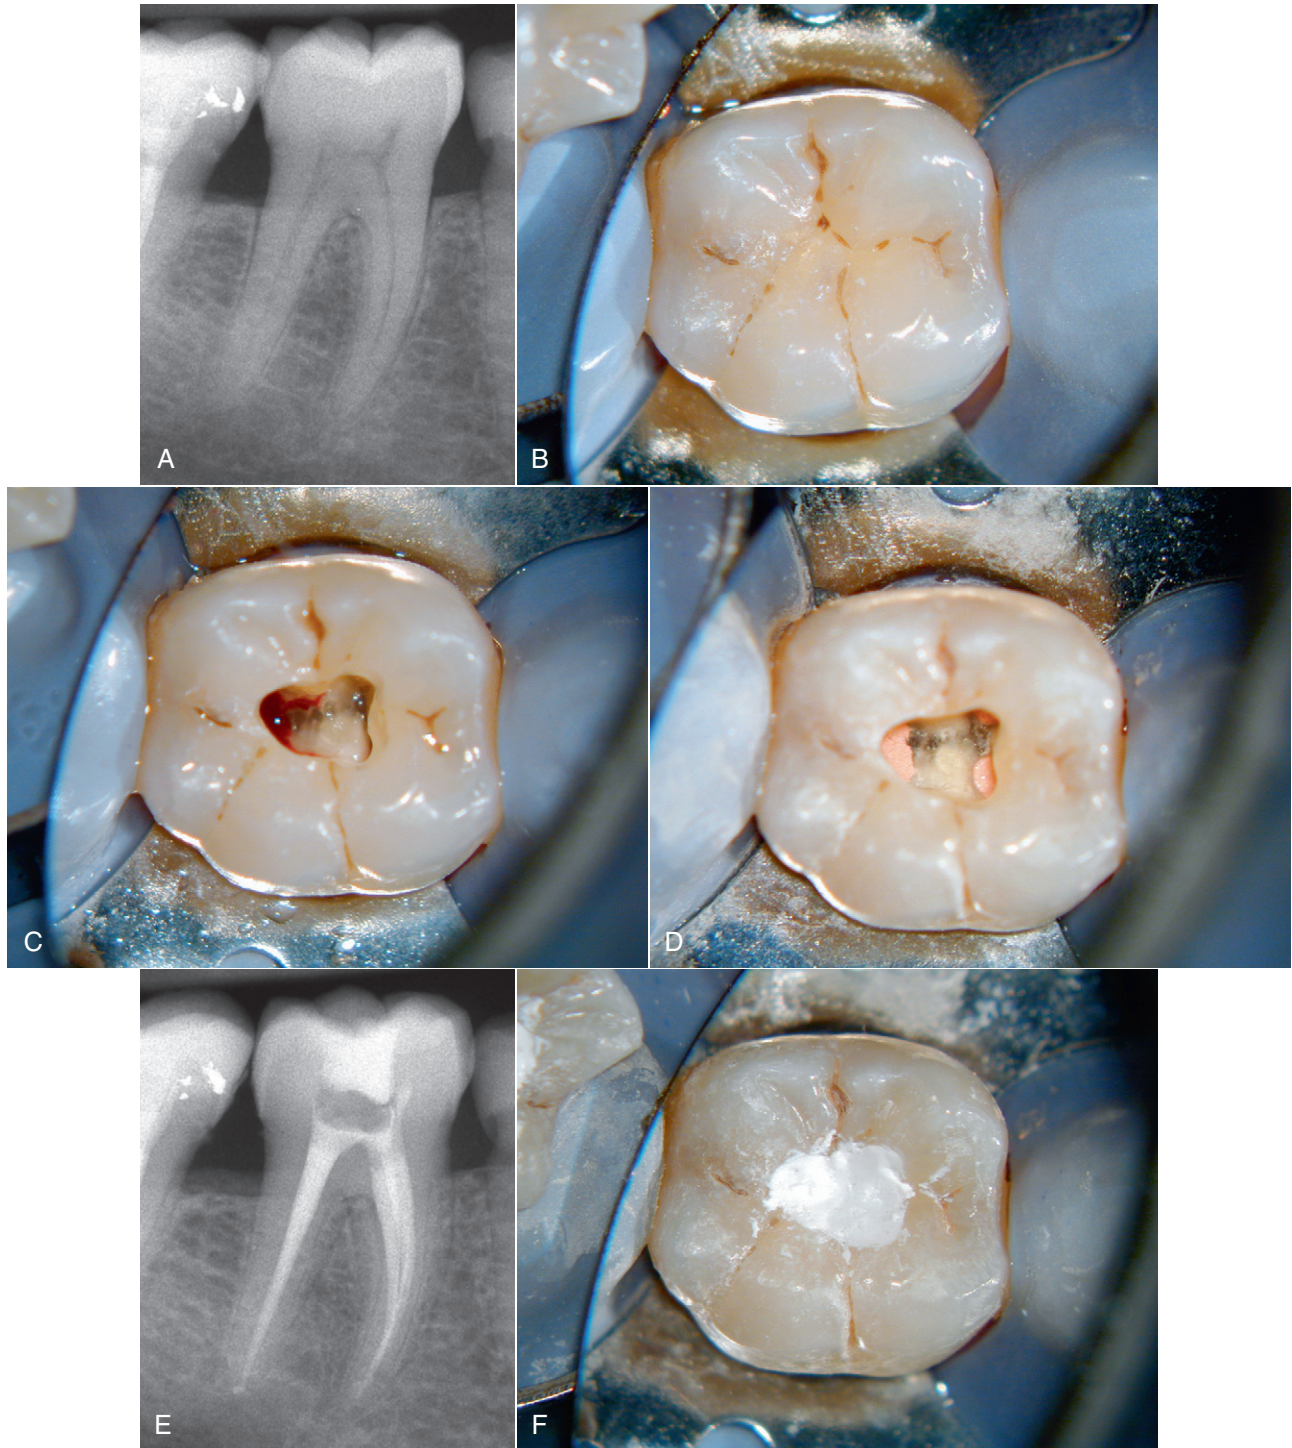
A recently restored tooth (porcelain overlay) that has become symptomatic. A, Radiograph of restored tooth—changes in pulpal tissue suggest biologic degenerative changes. B, Preendodontic view. C, Profuse bleeding indicating pulpal inflammation. D, Finished endodontic treatment. E, Final radiograph of restored tooth. F, The restoration in need of repair. How does the patient feel about it? Could this situation be prevented by evaluating the pulpal status before restoring? (*E* Courtesy of Dr Carlos Bóveda)
